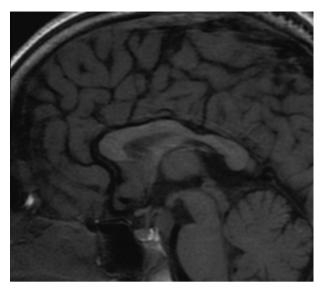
Magnetic resonance imaging of the brain. A hypothalamic hamartoma was detected as an isointense hypothalamic mass of $0.9~\mathrm{cm} \times 1.1~\mathrm{cm} \times 1.2~\mathrm{cm}$ in the tuber cinereum. The tumor was classified as peduncular and parahypothalamic, and the third ventricle was not distored.
